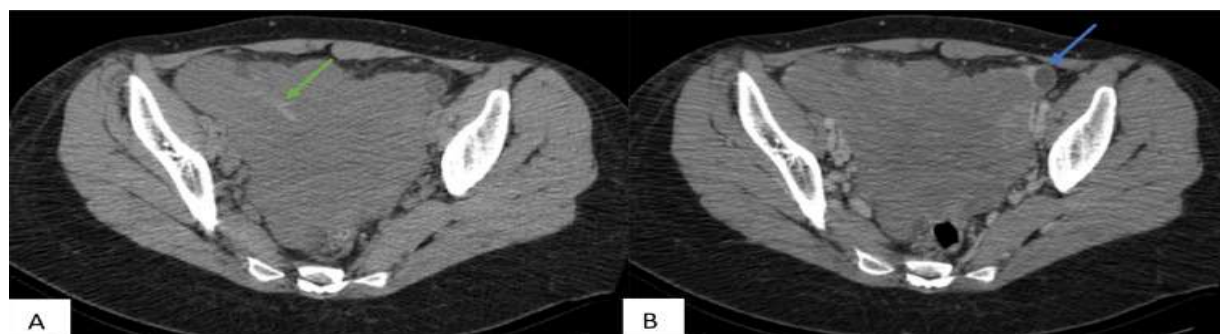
Axial computed tomography scans of the abdomen and pelvis before (A) and after contrast (B) show bilateral ovarian tumors with heterogeneous contrast enhancement, including hemorrhagic (green arrows) and cystic (blue arrows) areas.
